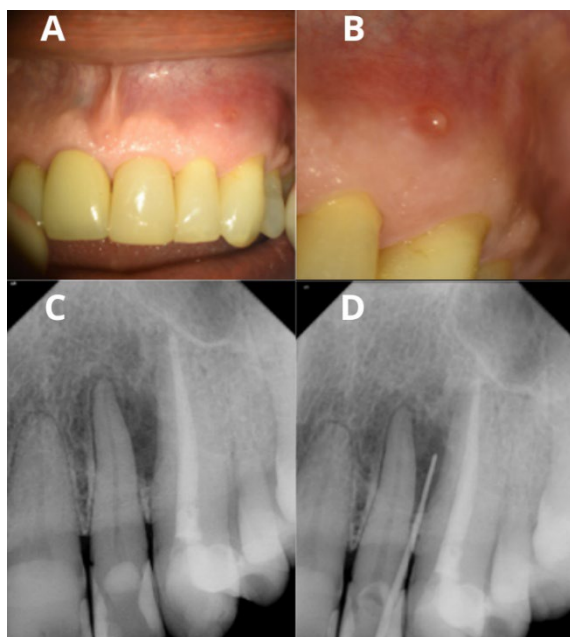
A) Patient at initial consultation; B) Sinus tract located between teeth #22 and #23; C) Initial diagnostic radiograph; D) Sinus tract identified by gutta-percha
